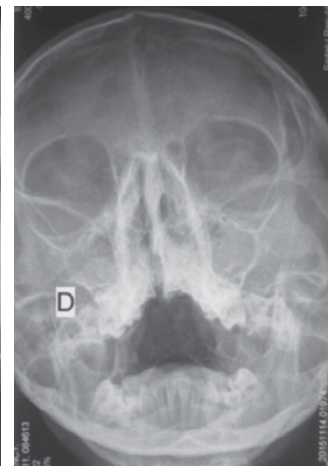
Patient C.*, 17 years old. X-ray of sinuses. For further explanations, see text
